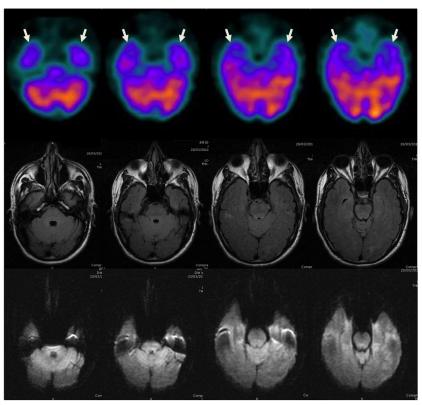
Comparison of brain SPECT and MRI findings in the same patient of Fig. 1 (37yo male) at follow-up. a: disappearance of the previously observed perfusion defect on right fronto-parietal cortex and onset of a new hypoperfused area on left fronto-parietal cortex (arrows). MRI FLAIR shows no significant changes compared with the previous study (arrowheads). DWI shows no significant abnormalities. b: hypoperfusion extension to the left temporal lobe pole at SPECT study (arrows). No focal alterations detected with MRI (FLAIR and DWI).
